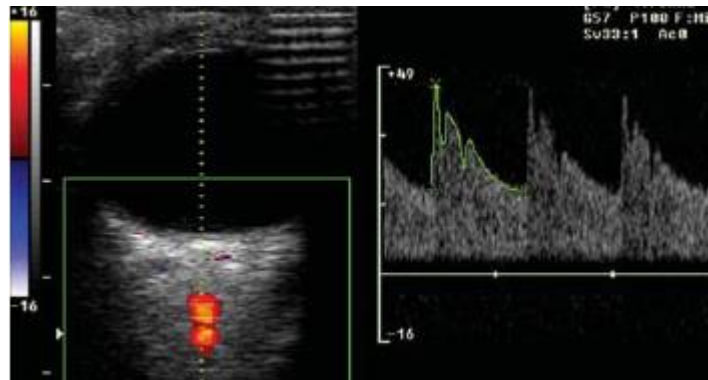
Imagem representativa da onda dopplerfluxométrica da artéria oftálmica de uma gestante normal.
